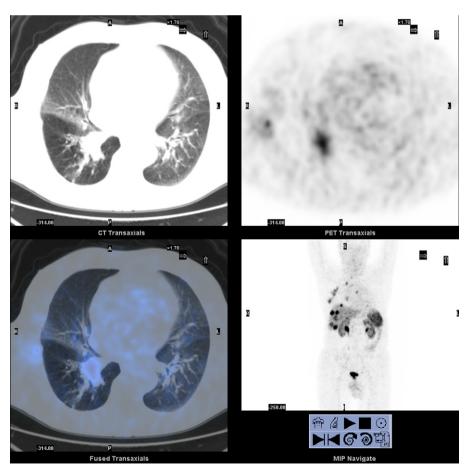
68Ga-DOTANOC PET/CT images of a patient with primary lung NET showing multiple lung, pleuric, lymphnodal, liver lesions with a high expression of somatostatin receptors.
